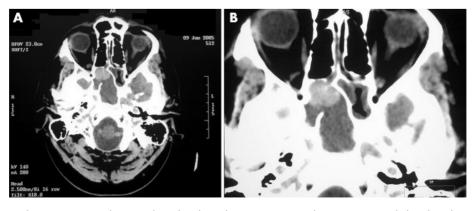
(A) CT scan showing opacity and mass in the right sphenoid sinus. (B) CT scan showing a mass occluding the sphenoid sinus ostium.
